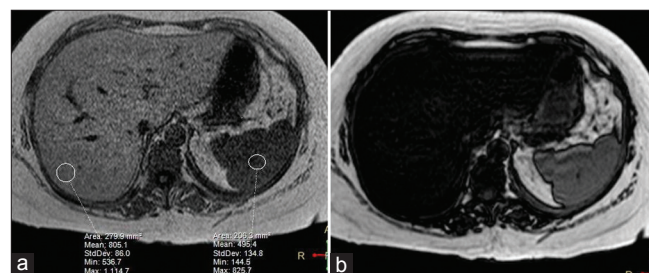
Chemical shift imaging. MRI image shows (a) in-phase image with a hepatic to splenic signal intensity ratio of 1.6 (b) opposed-phase shows signal drop in liver due to diffuse fatty infiltration
